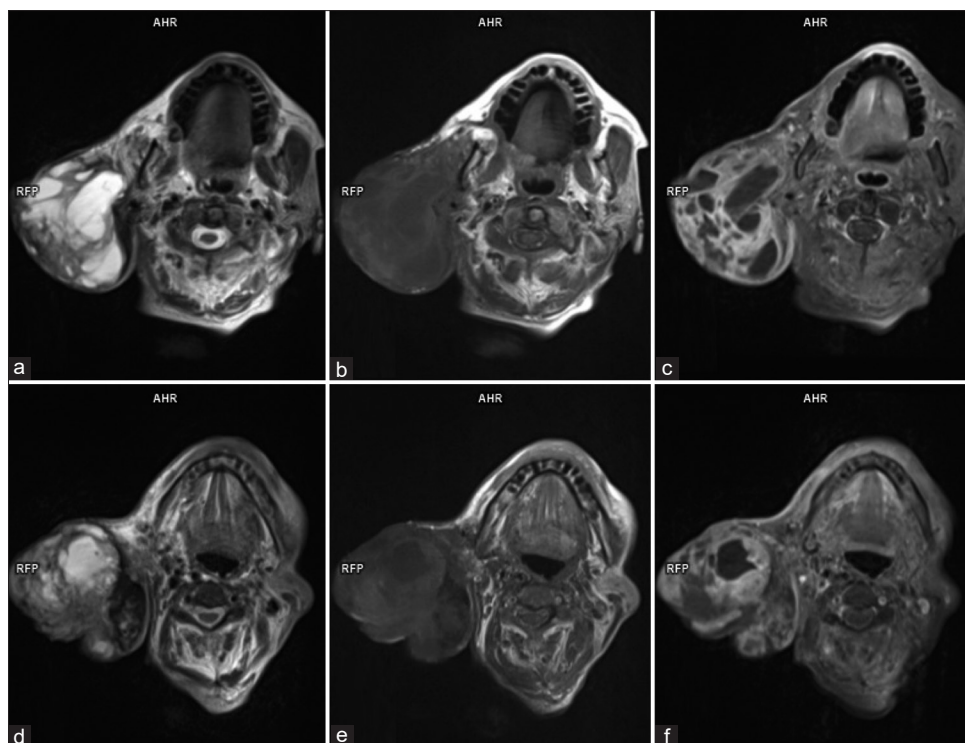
(a and d) Axial T2-weighted magnetic resonance imaging. (b and e) Axial T1-weighted magnetic resonance imaging. (c and f) Postcontrast axial T1 fat-saturated magnetic resonance imaging images. Hypo- to isointense large exophytic lesion on T1-weighted images with hyperintense solid-cystic lesion in T2-weighted images. On contrast administration, intense contrast enhancement noted in the solid component of the lesion with multiple intervening cystic areas suggestive of necrosis. Superficially, the lesion is involving the overlying skin and subcutaneous tissue with ulcerative changes. Anteromedially, it is infiltrating into the right masseter and abutting the outer cortex of the right ramus and the angle of the mandible. Medially, the lesion is involving the deep lobe of the right parotid gland, right parapharyngeal space, and right lateral pterygoid muscle. Few enhancing right cervical level II lymph nodes are noted
